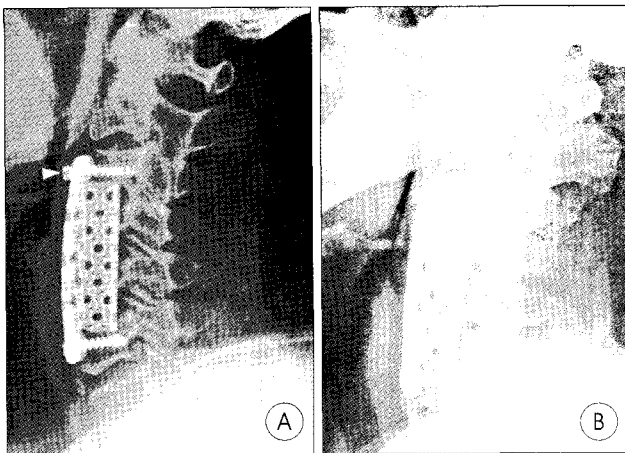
A : Lateral radiograph of failure of a 2-level corpectomy reconstruction using a 13-mm titanium mesh cage 2.5 months after decompression of ossification of the posterior longitudinal ligament. The screw has pulled out of the cephalad part of the vertebral body (arrowhead). B : Lateral radiograph 6 months after surgery demonstrating a non-union with presence of peri-implant lucencies (white arrow).
